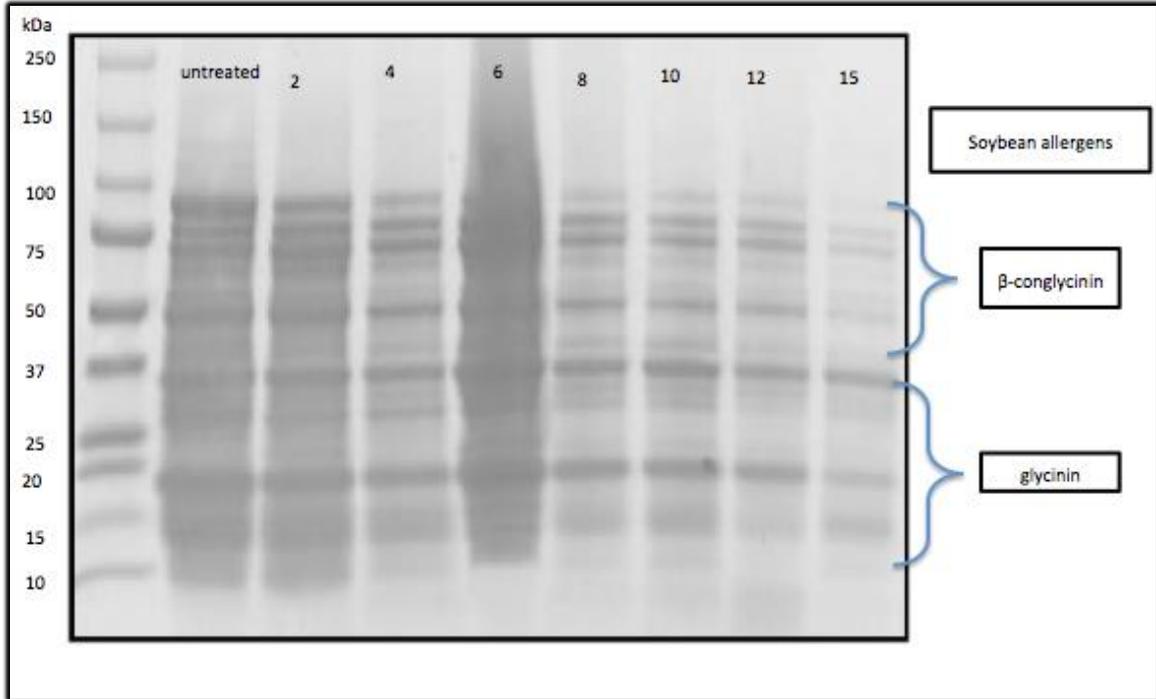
SDS-PAGE profile of soybean extracts treated with power ultrasound for 2, 4, 6, 8, 10, 12, and 15 min, compared to untreated extract. Molecular weights are expressed in kDa.
